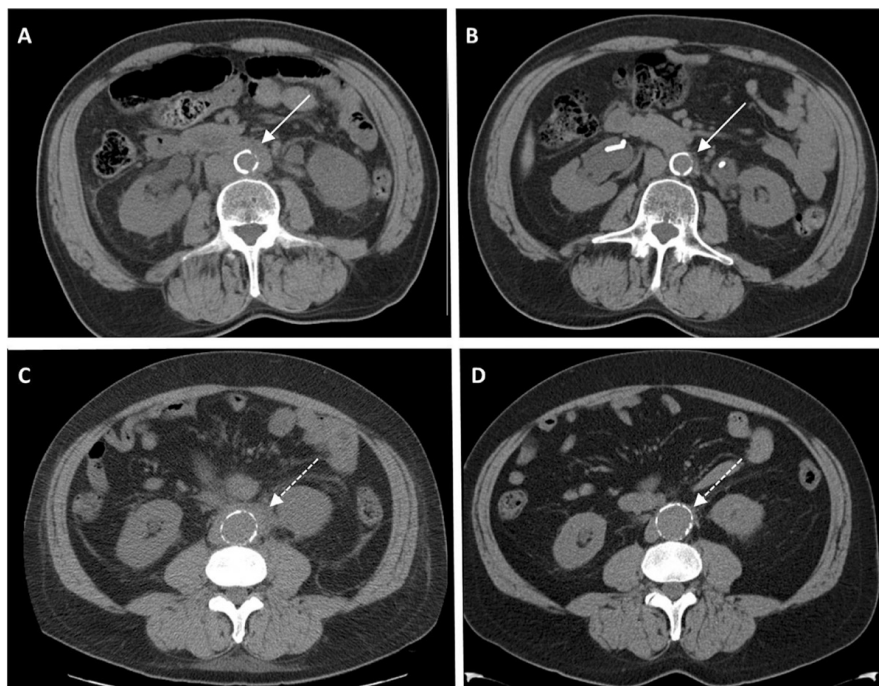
Cross-sectional non-contrast computed tomography imaging demonstrating initial and follow-up imaging in representative patients with non-aneurysmal, isolated chronic periaortitis (panel A: before, panel B: after treatment) and aneurysmal, isolated chronic periaortitis (panel C: before; panel D: after treatment).
